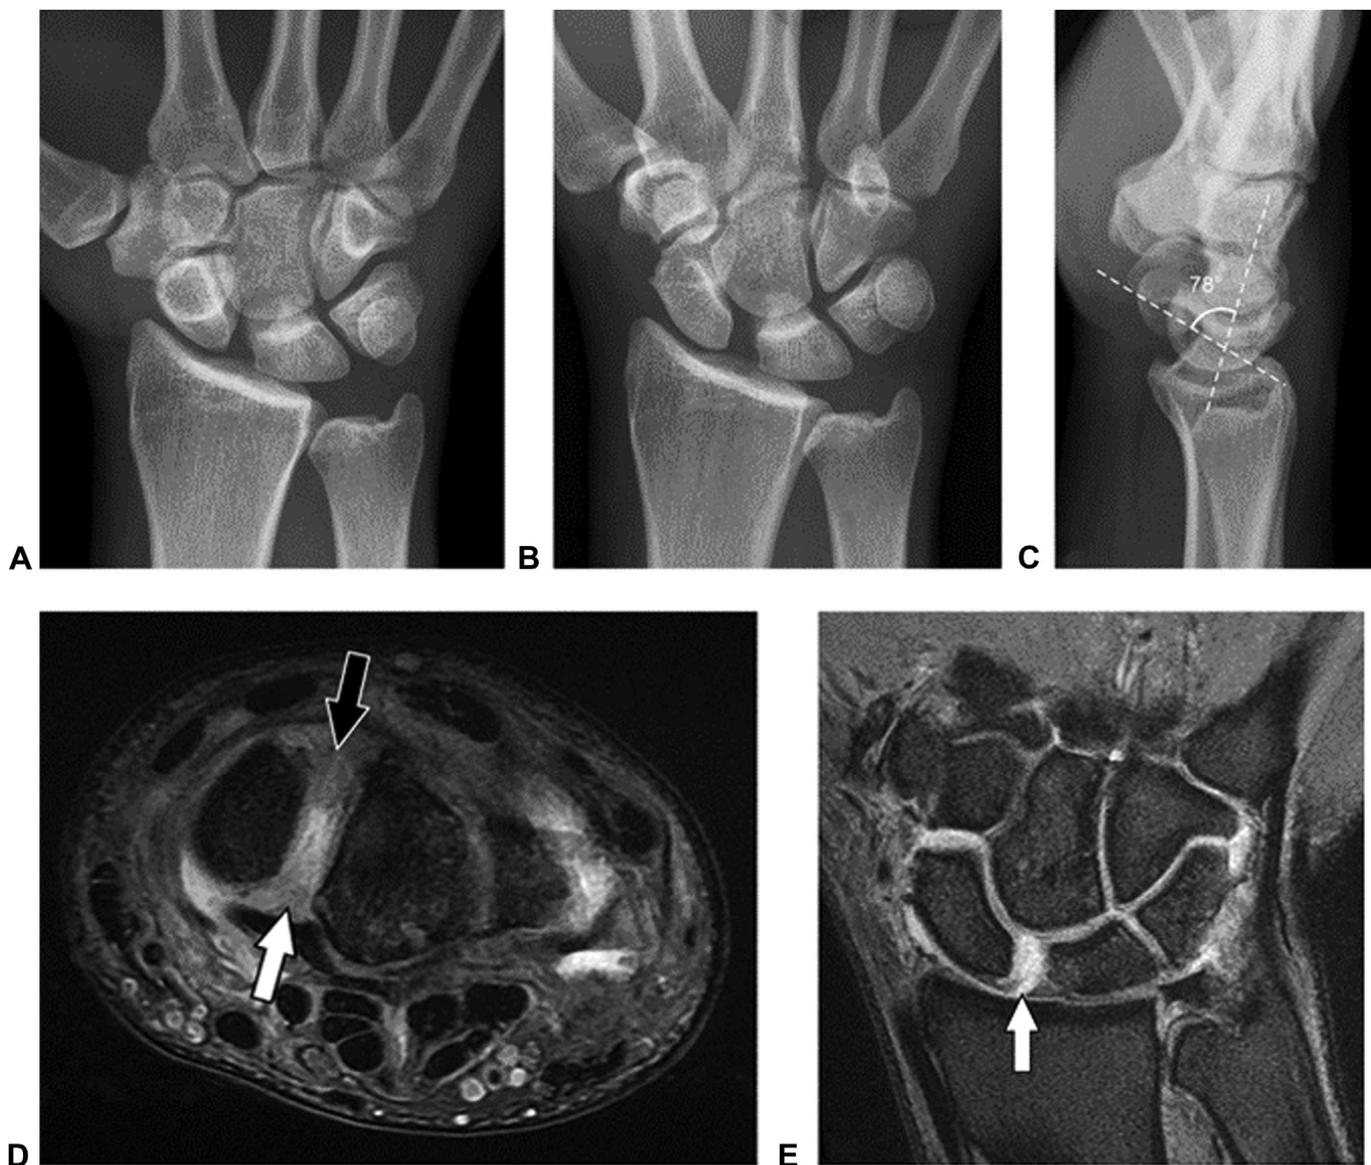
Stage 3 reducible malalignment in a 23-year-old professional American football player with a remote injury. A Static posteroanterior radiograph shows a scapholunate interval of 4.5 mm. B Dynamic clenched fist radiograph shows an increase in scapholunate interval to 5 mm. C Lateral radiograph shows that the scapholunate angle is increased to 78° with dorsal tilting of the lunate, compatible with DISL. D Axial PDW fat-suppressed MR image shows a torn SLL dorsal band (black arrow) and torn SLL volar band (white arrow) with scar tissue. E Coronal PDW fat-suppressed MR image shows a tear (arrow) of the SLIL interosseous band and scapholunate interval widening. Stage 3 reducible malalignment and stage 4 irreducible malalignment injuries have similar imaging appearances and are differentiated on the basis of reducibility during fluoroscopic traction or surgery. If the malalignment is reducible during fluoroscopic traction or surgery, the patient can undergo SLIL reconstruction. If the malalignment is not reducible, the patient can undergo a salvage procedure. (Adapted with permission from Palisch et al¹⁰¹).
